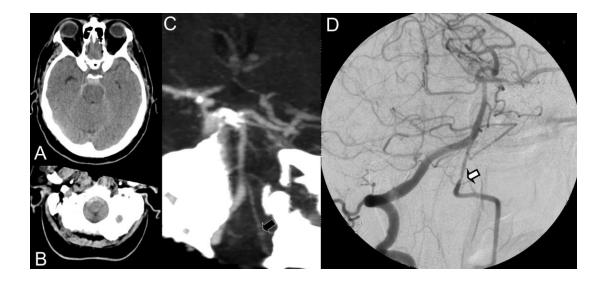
An abnormality beyond detection with CTA in a patient with a perimesencephalic pattern of haemorrhage with extension to the foramen magnum. Non contrast CT (A and B) demonstrating a perimesencephalic pattern of SAH with extension to the foramen magnum. Coronal CTA (C) demonstrating minimal detectable abnormality of a hypoplastic V4 segment of left vertebral artery (black arrow). Oblique frontal projection DSA (D) demonstraing an irregular stenosis of the left vertebral artery (white arrow) interpereted as a potential dissection at time of angiography.
